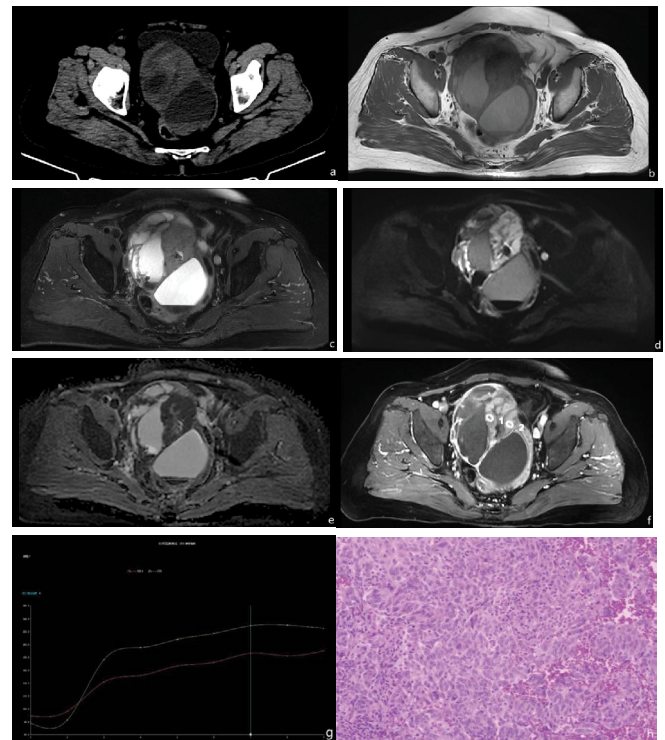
Ovarian adult granulosa cell tumor with sarcomatoid transformation. a CT showed a large cystic-solid mass in the right adnexal region, containing a fluid-fluid level suggestive of intratumoral hemorrhage. b On T1WI sequences, the mass demonstrated heterogeneous signal intensity with mixed isointense and hyperintense areas. c T2WI and fat-suppressed T2WI sequences showed markedly heterogeneous signals comprising high, intermediate, and low intensities, along with a fluid-fluid level, further supporting the presence of hemorrhage. d DWI with b-values of 50 and 800 showed that the solid components of the tumor exhibited progressive hyperintensity. e The ADC showed that the solid component of the tumor was a low signal. In contrast, the cystic portions showed no diffusion restriction. Persistent hypointense areas and a fluid-fluid level within the lesion were consistent with a hemorrhagic cystic-solid tumor. f DCE scanning showed the blood supply of the tumor region was abundant, and it was obviously enhanced in the early stage and continuously. g The dynamic enhanced scan curve showed a type II time-intensity curve. h The pathology results showed that the tumor cells were of varying sizes, with oval, spindle-shaped or irregular nuclei, characteristic Call-Exner bodies, and abundant cytoplasm that was acidic and presented a watery-like or irregular arrangement.
